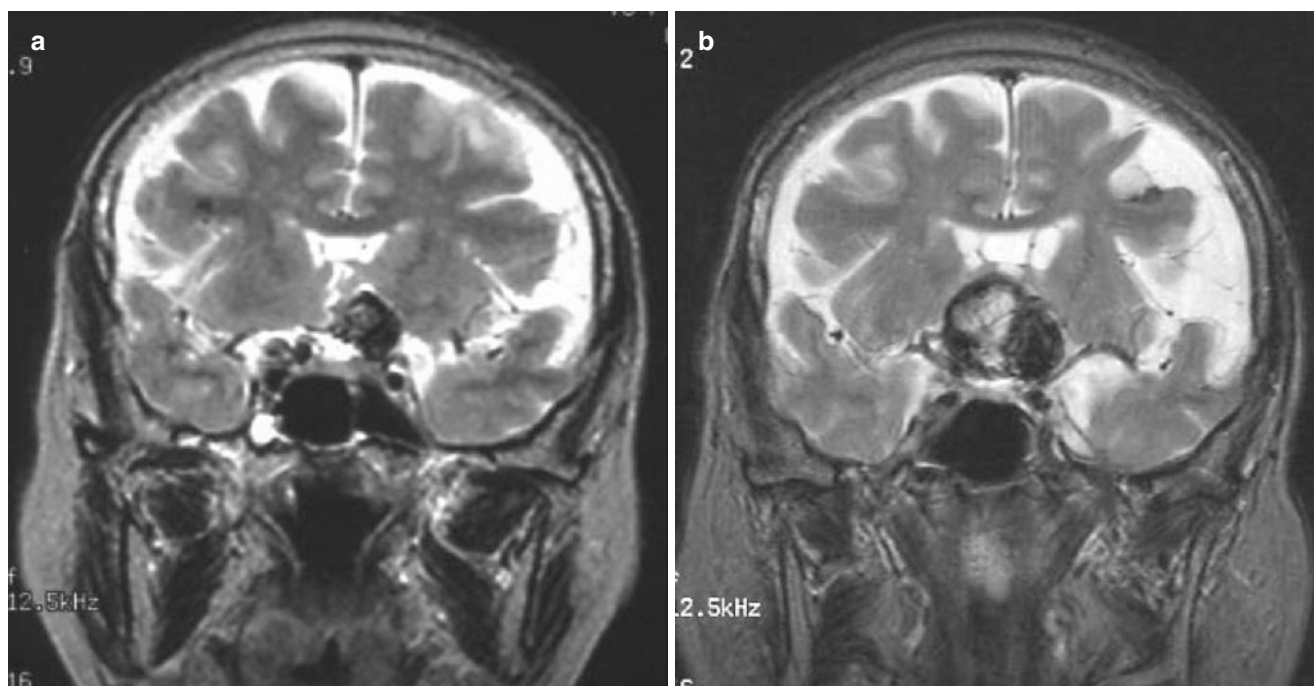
(a) MRI demonstrating a left IC-ophthalmic large aneurysm. (b) MRI obtained 3 years later showing remarkable recanalization and regrowth of the aneurysm following incomplete coil embolization
